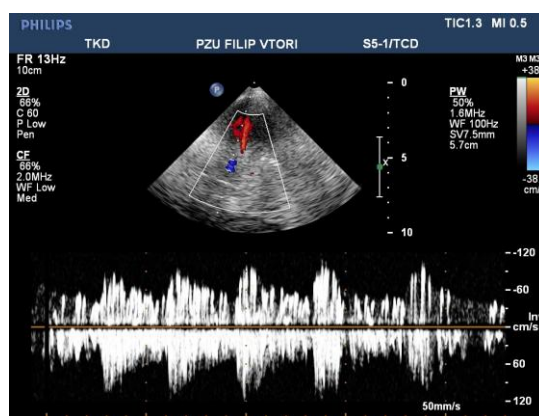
Transcranial doppler ultrasound (TCD) in a patient with large PFO (over 40 bubbles)
